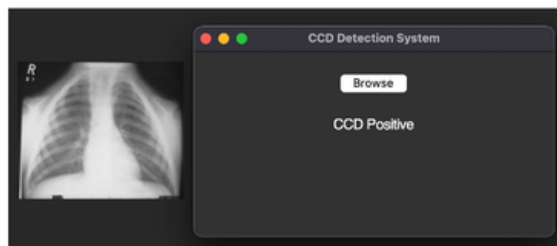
The CCDDS user interface contains a functionality to browse for a thoracic radiograph (as shown in the left of the image), and select for testing. It will then display the result of "CCD Positive" or "CCD Negative"
